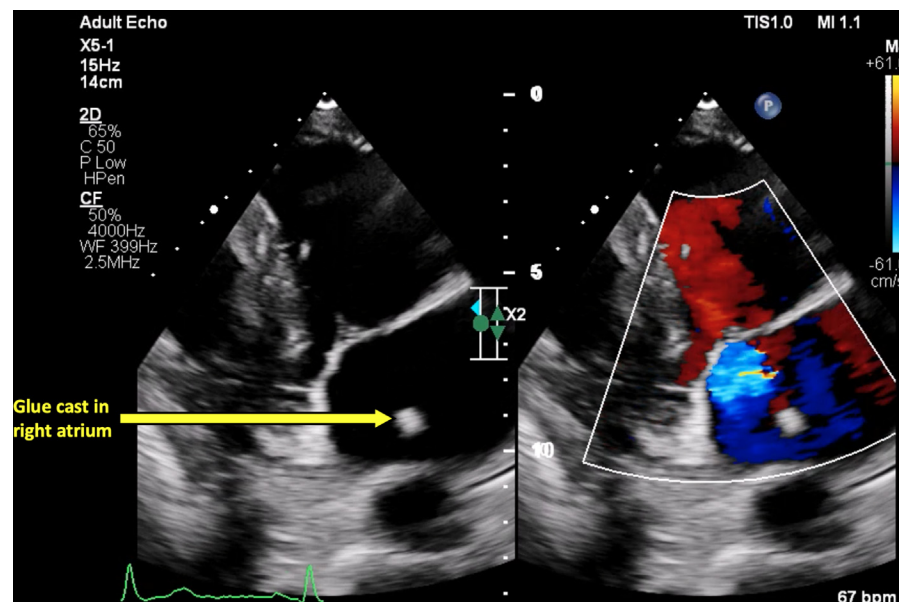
Echocardiography Demonstrating Echogenic Glue Cast in Right Atrium
